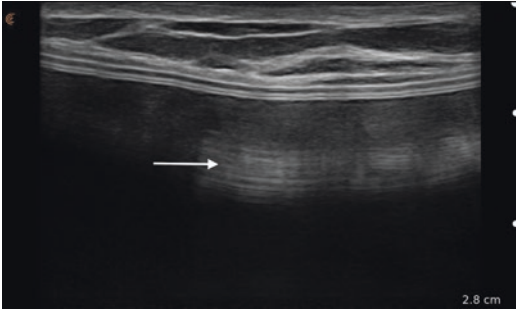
Grayscale ultrasound image of smooth silicone gel breast implant. Arrow shows reverberation artifact of implant elastomer shell
